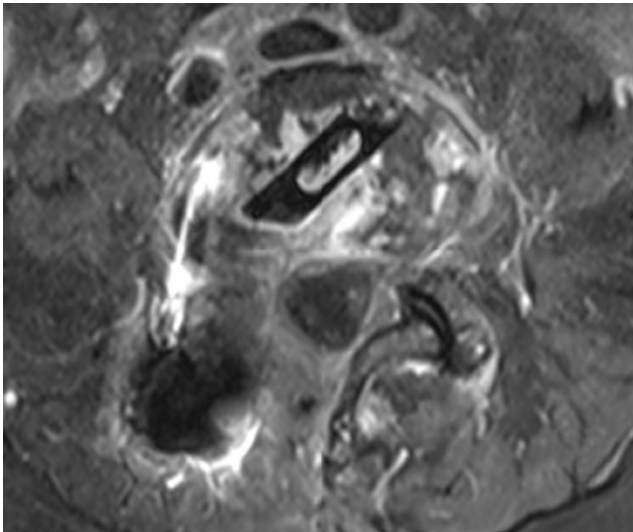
MRI showing a 65-year-old man with intervertebral disc infection
